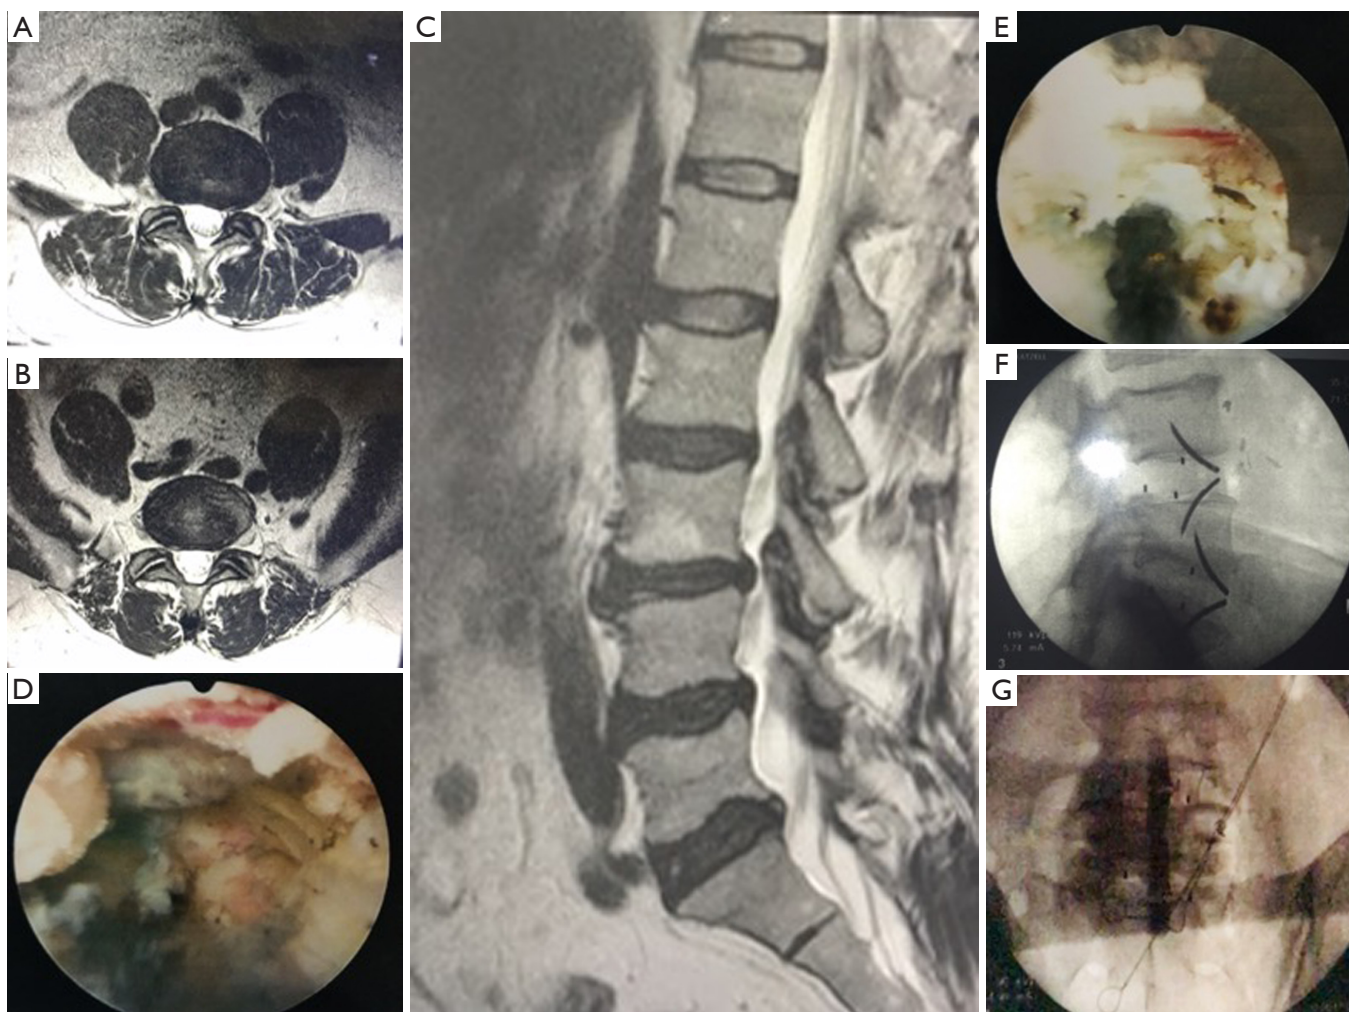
Exemplary case of a 61-year-old male complaining of low back pain and right lower extremity radiculopathy to the foot both level 8 in severity 3 months after a motor vehicle accident. The patient suffered from facet joint degeneration and had a history of alcohol abuse and had a BMI of 28. Physical examination revealed loss of lumbar lordosis, paraspinal muscle spasms, tenderness over the lumbar facet joints, and decreased range of motion to flexion and extension. The patient had a positive straight leg raise on the right side. (A,B,C) The MRI scan showed L3–4 disc bulge with facet fluid and hypertrophy, L4–5 left paracentral herniation with annular tear and bilateral facet hypertrophy, and L5–S1 left paracentral disc herniation with facet degeneration and fluid suggestive of instability; (A,B) the axial cuts also suggested foraminal stenosis noted at L4–5, L5–S1 due to facet degeneration. Initially, the patient was treated with a left-sided endoscopic discectomy at L4–5 and L5–S1; (D,E) intra-operative findings showed large annular tears with annular insufficiency. The postoperative course showed no relief of axial pain and dysesthesia radicular pain due to irritation of the dorsal root ganglion; (F,G) this patient had three risk factors: large annular defects, facet degeneration, stenosis. Ultimately, an ALIF was performed to lessen both axial and radicular pain. BMI, body mass index; MRI, magnetic resonance imaging; ALIF, anterior lumbar interbody fusion.
